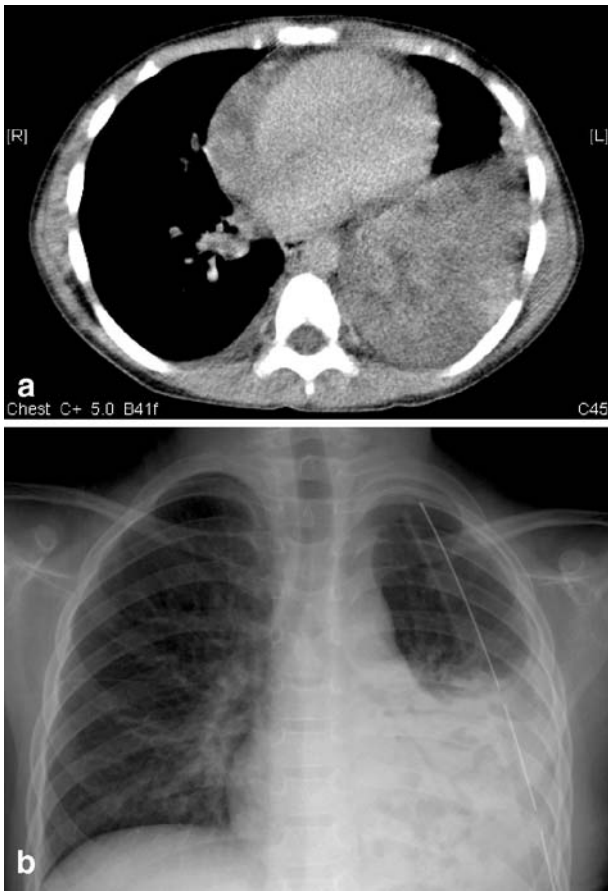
a A contrast-enhanced CT scan taken on the 4th day following admission. The left lower lobe shows total consolidation with multiple low attenuation change, indicating diffuse and severe necrosis of the lung. b A posteroanterior chest film on the 14th day following admission. Multiple pneumatoceles are formed in consolidated lung over left lower lobe. A thoracotomy tube is placed with effective drainage of pleural fluid
